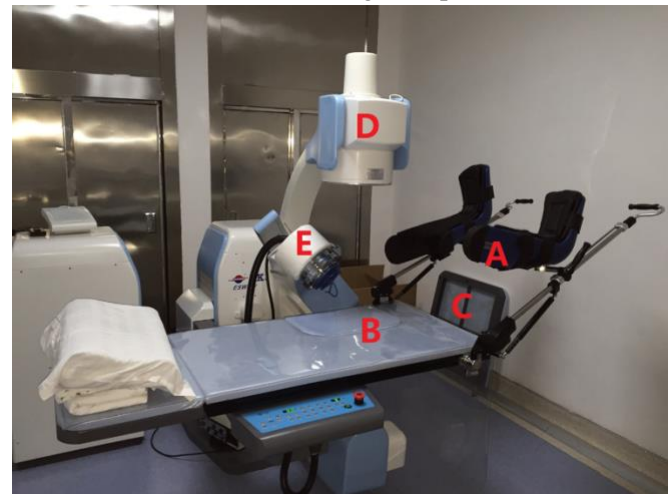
A pair of Power-lift Stirrups (A) was integrated with both sides of lithotripsy table (B) after the detachable tail portion (C) was detached and the optimum fluoroscopic view of X-ray C-arm (D) was achieved by adjusting the shock wave generator (E).
